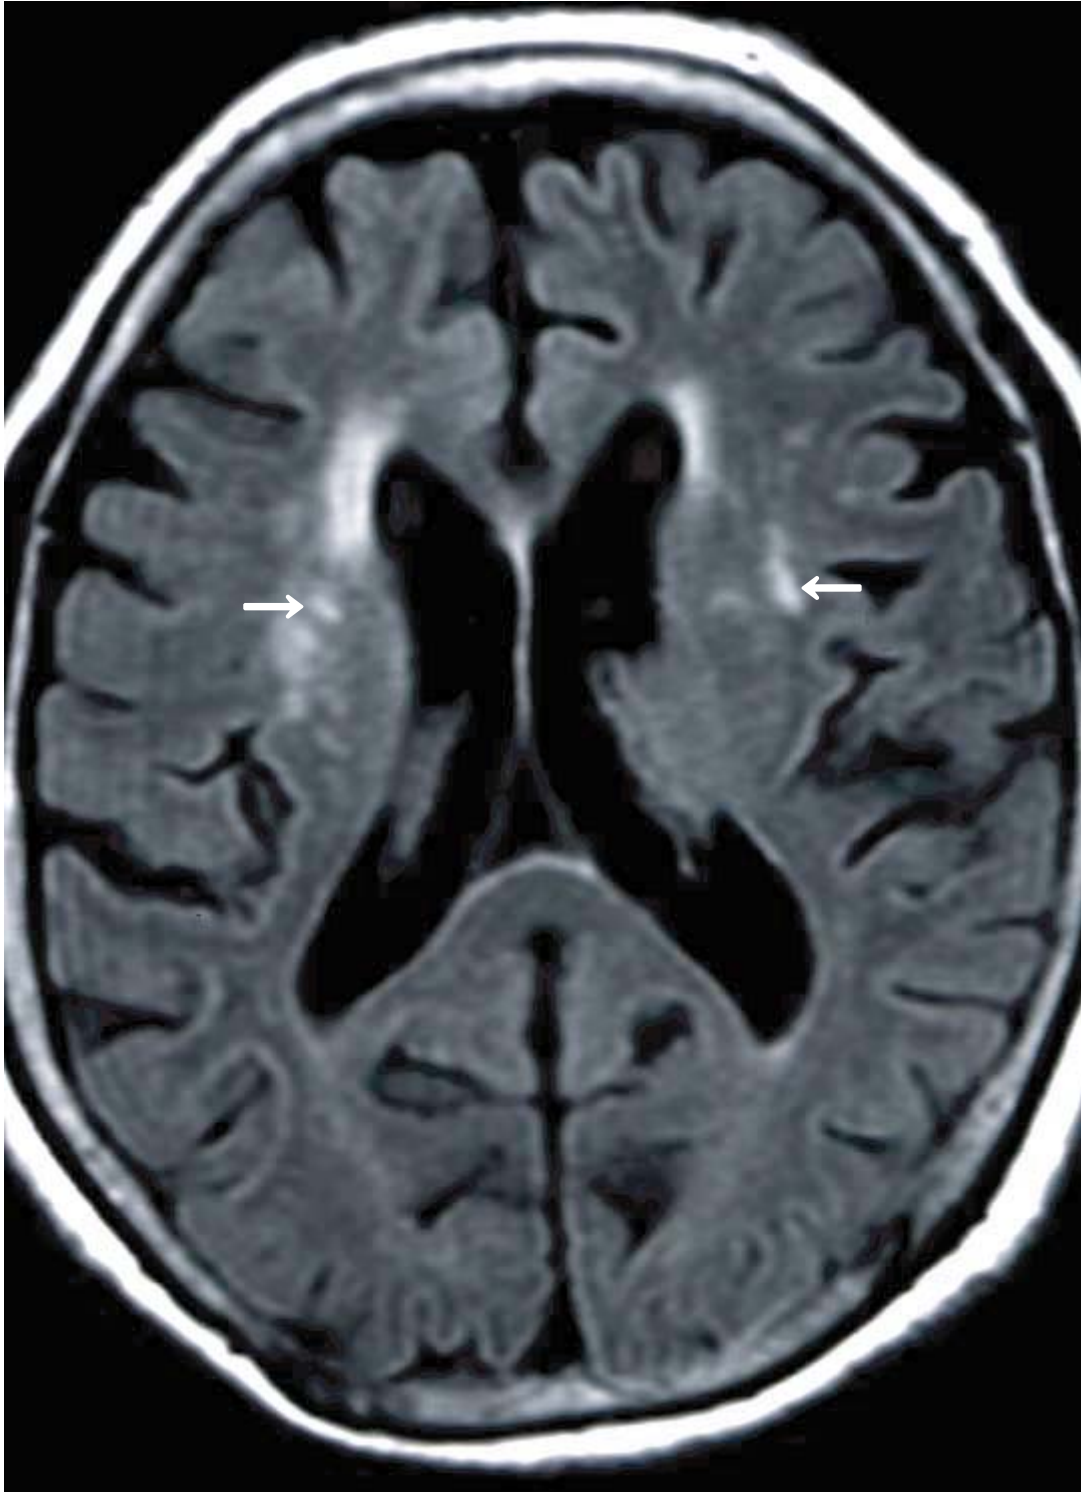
Brain MRI of case 1 (T2 FLAIR). Deep white matter hyperintensity is observed in bilateral basal ganglia (white arrows).
